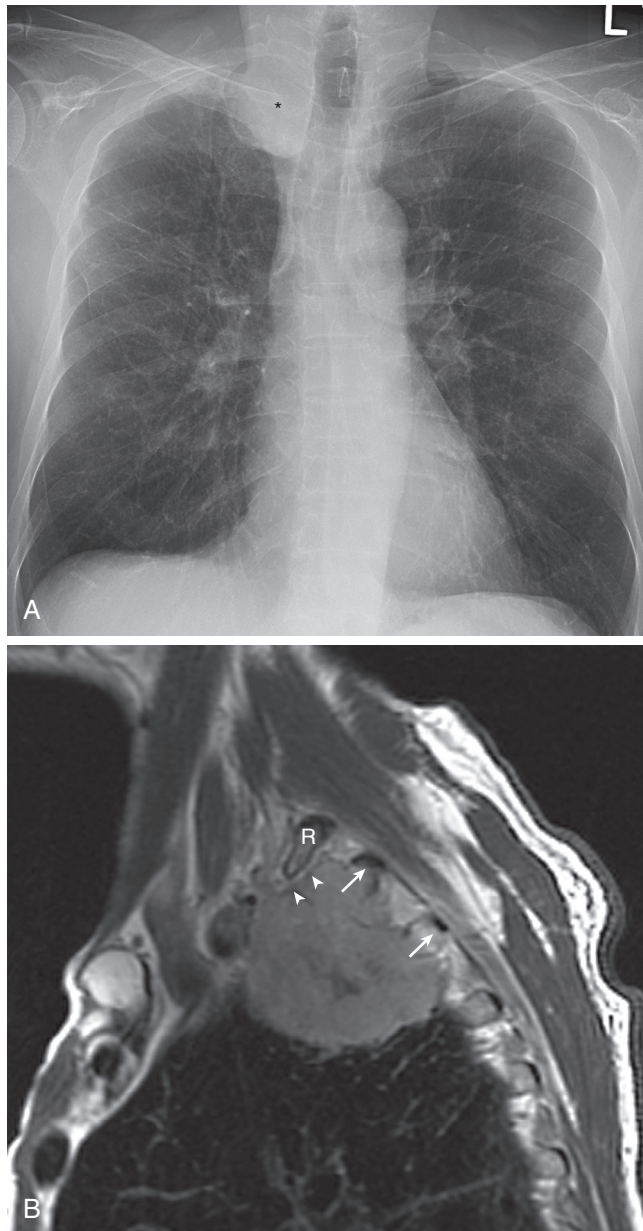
■ Non-small-cell lung cancer superior sulcus tumor. A, Posteroanterior chest radiograph shows a right upper lobe mass (asterisk). B, Sagittal magnetic resonance imaging shows a mass invading the second and third ribs (arrows). Preservation of adjacent soft tissue planes (arrowheads) adjacent to the first rib (*R*) indicates that the C8 nerve root of the brachial plexus located superior to the rib is not involved by tumor and the patient is potentially a surgical candidate.
